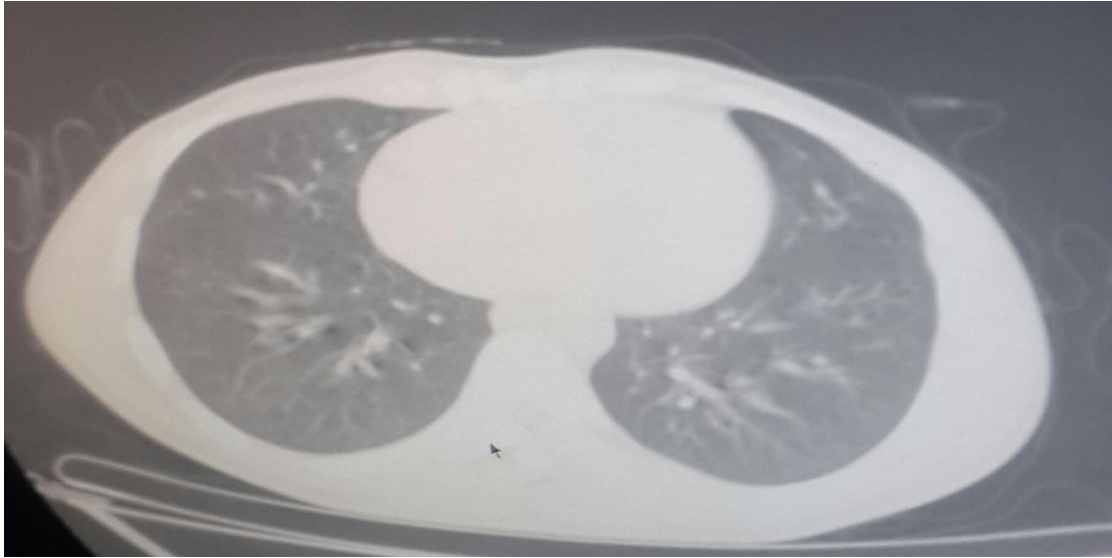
CT chest for male 19 years old bilaterally sub-pleural pathy
